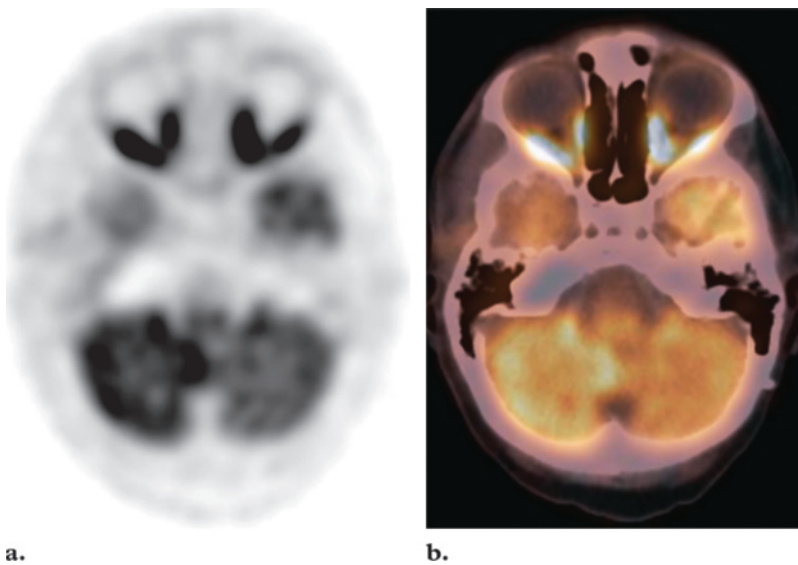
Transverse FDG PET scan (a) and fused PET/CT image (b) show bilateral marked uptake in the medial and lateral rectus muscles of the head.
